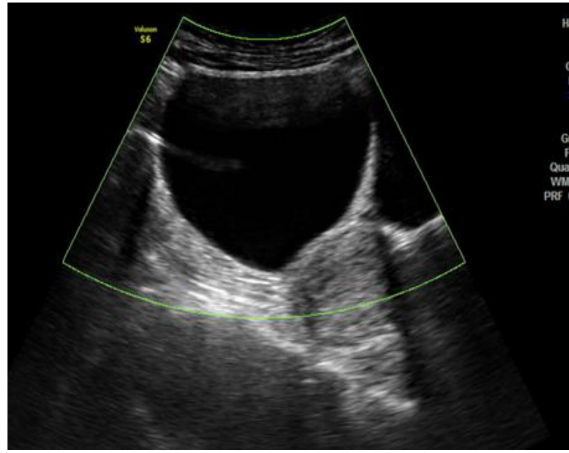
On color Doppler, no vascularity detected---Benign Ovarian Cyst
